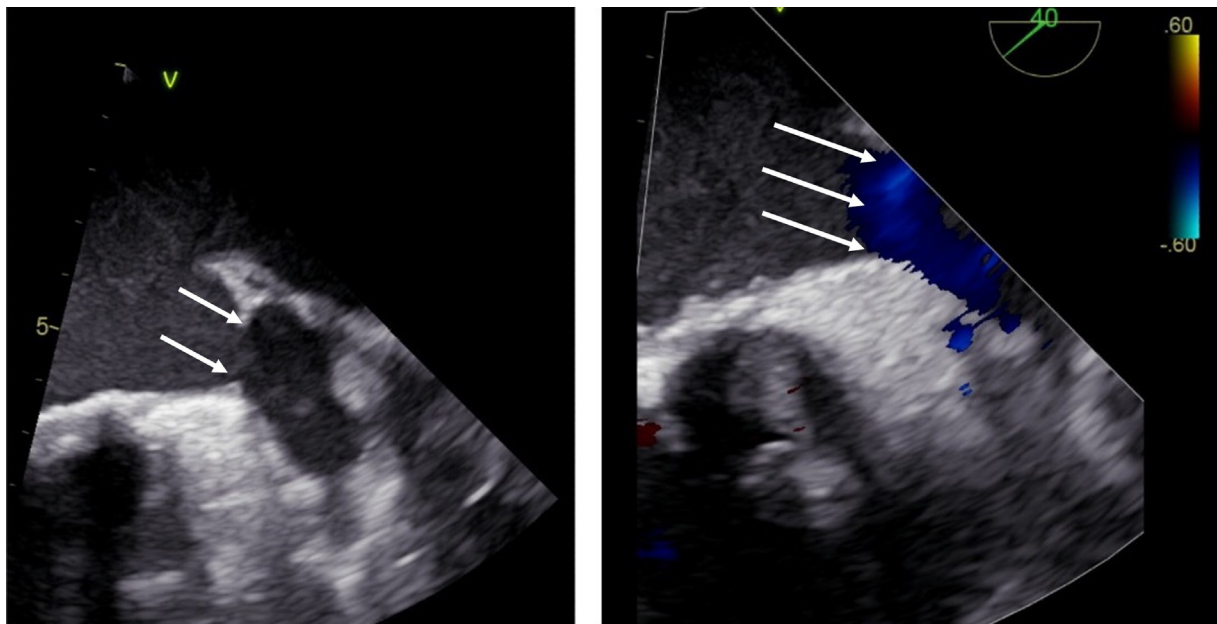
TEE showing unsuccessful LAA closure after external LAA ligation. Spontaneous contrast is shown in the LAA and Doppler color flow from LA into the LAA (white arrows). TEE, Transesophageal echocardiography; LAA, left atrial appendage.
